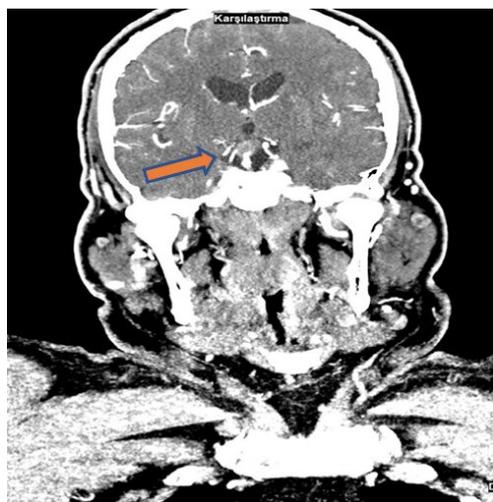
15x11mm thrombosed basilar artery aneurysm distal to the basilar artery in cranial CT angiography imaging (red arrow)
